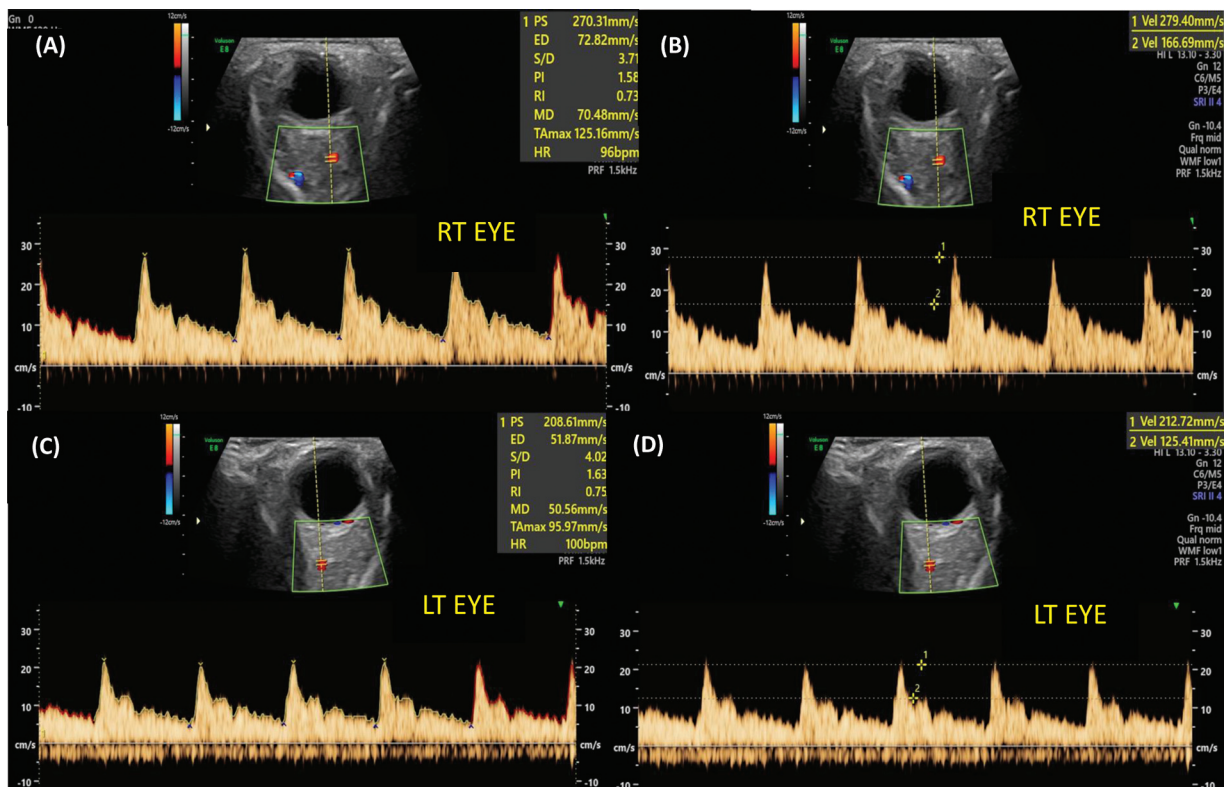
This spectral Doppler represents the various parameters of the ophthalmic artery velocimetry measured alternatively from both eyes. All the parameters are measured automatically (A and C) except the first and second peak systolic velocity, which were measured manually (B and D).
